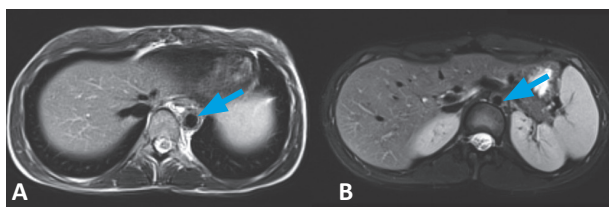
Magnetic resonance angiography (axial view, T2-weighted image) showing the thickening of the thoracic aorta (arrow) (A). Magnetic resonance angiography (axial view, T2-weighted image) showing the thickening of the abdominal aorta (arrow) (B).
